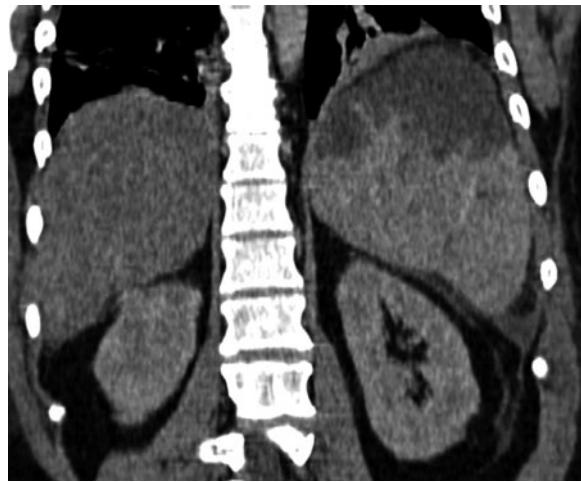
Acute splenic sequestration crisis. Coronal contrast-enhanced CT scan in a patient with sickle cell disease showing splenomegaly and nonenhanced areas consistent with partial splenic infarction
